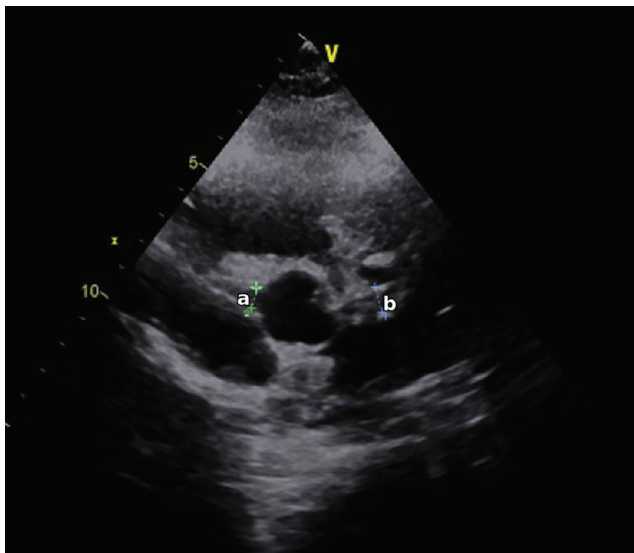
Image of aneurysms observed on transthoracic echocardiography at the time of diagnosis aneurysm (a) RCA aneurysm (b) LCA aneurysm RCA: Right coronary artery, LCA: Left coronary artery
